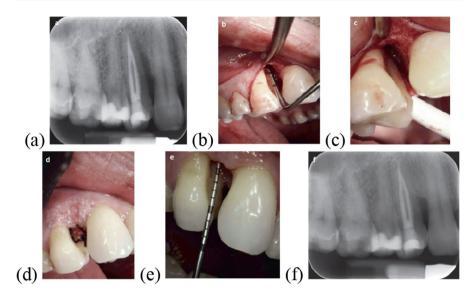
a Radiograph showing 11 mm pocket on the mesial aspect of the maxillary first premolar remaining after initial therapy. b After removal of subgingival calculus with ultrasonic instruments, a flap is raised, and the bone defect is explored with a periodontal probe. c Immediate postoperative view of the debrided infrabony pocket. An Er,Cr:YSGG laser was used with a 600- μ -diameter contact tip. To remove granulation tissue from the hard and soft tissues, an average power of 1.5 W (50 mJ, 30 Hz) was used with 50% air and 40% water spray in the short pulse mode. The smear layer was also removed from the root surface and bone tissue with an average power of 0.75 W (15 mJ, 50 Hz) with 50% water and 40% air. d The sutured flap. e 8-Month postoperative view showing good reattachment with slight gingival recession. f 8-Month postoperative radiograph showing a more stable periodontal condition with bone regeneration (Clinical case courtesy of Dr. Rana Al-Falaki)
